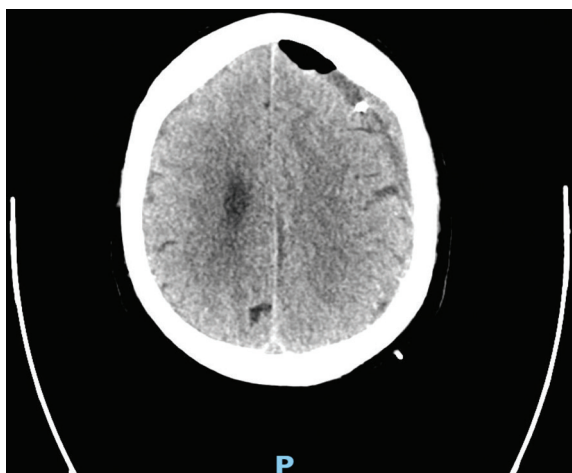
Repeat computed tomography post-surgery showing an overall decrease in the subdural collection volume, midline shift, and prominence of the ventricular system.
